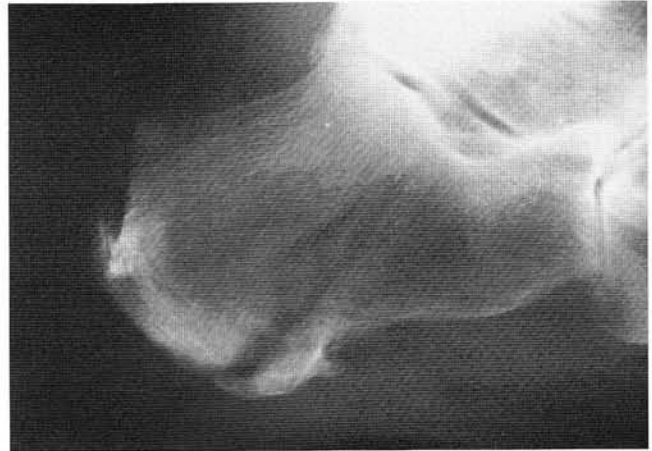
Lateral radiograph of the calcaneus reveals a sinus tract coursing through the posterior aspect of the calcaneus and ending close to the subtalar joint.
